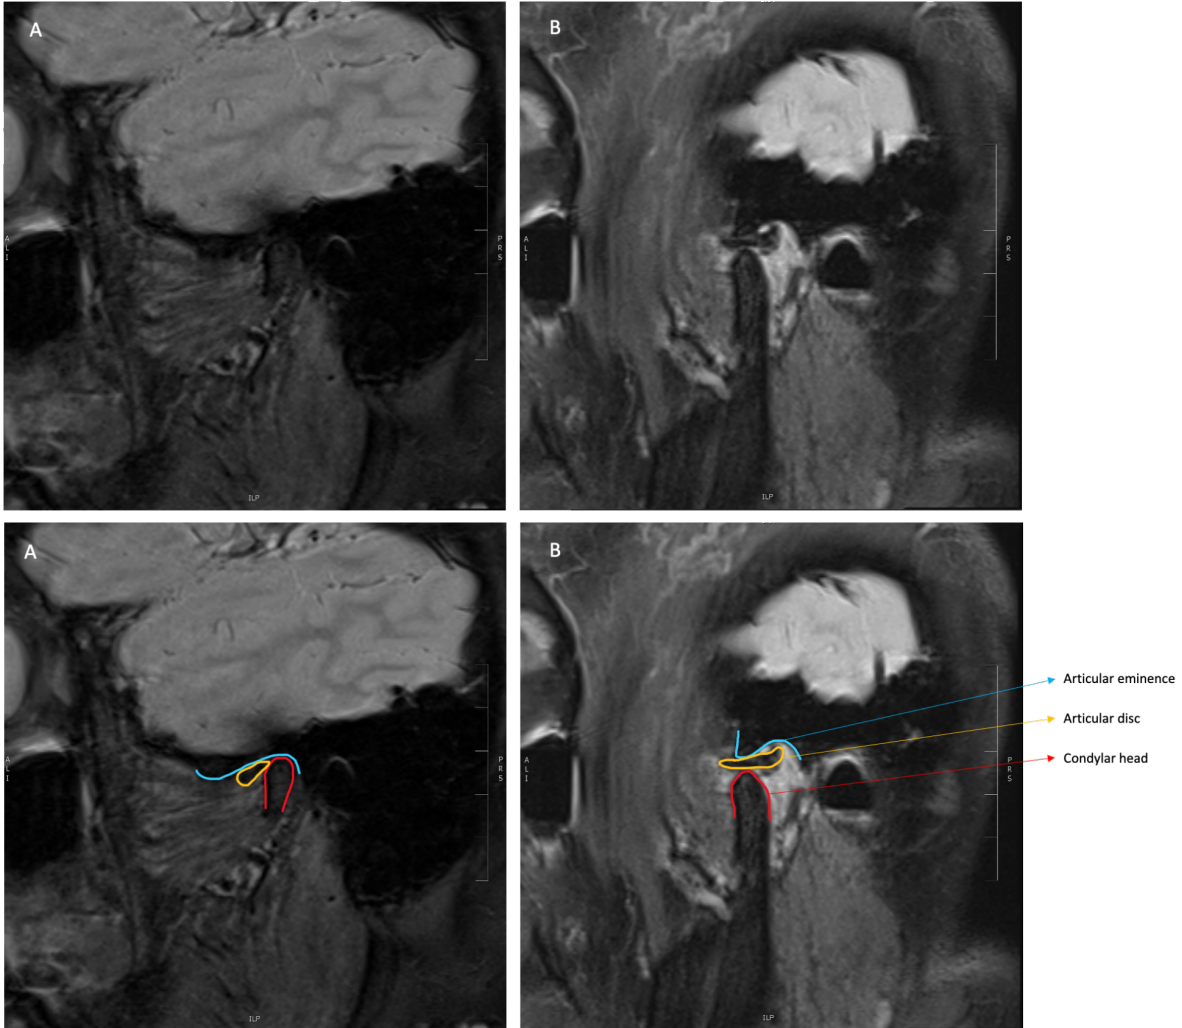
MRI sagittal view of right TMJ. MRI sagittal view of right TMJ demonstrating A) ADD in closed position and B) adequate recapture of the disc on opening.
